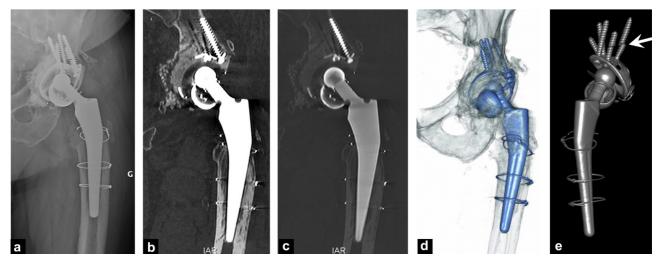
Preoperative computed tomography (CT) scan of a multioperated 83-year-old man shows implant loosening with component migration and screw fractures (arrow): a: conventional radiography; b and c: multiplanar reconstructions in the coronal plane of an (iterative reconstruction) with bone and implant component window settings to respectively assess bone and implant components; d and e: 3D reconstructions (volume rendering technique [VRT]) based on images obtained with iterative reconstruction provide a global view of the migration and implant fractures.
